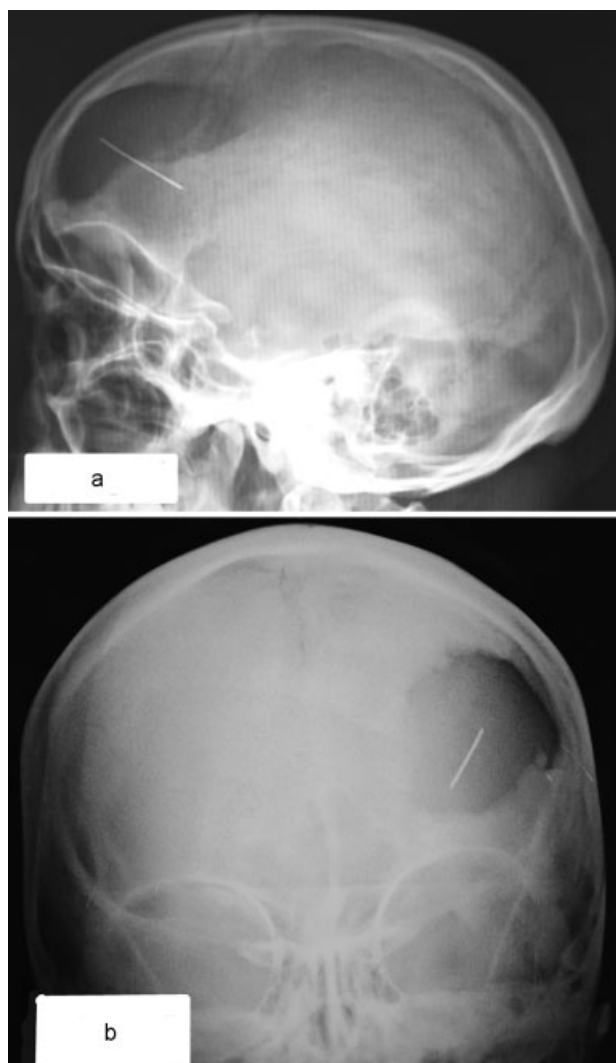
X-ray of a skull: (a) lateral view and (b) anteroposterior view. Left frontal bone defect with a needle seen in it.
